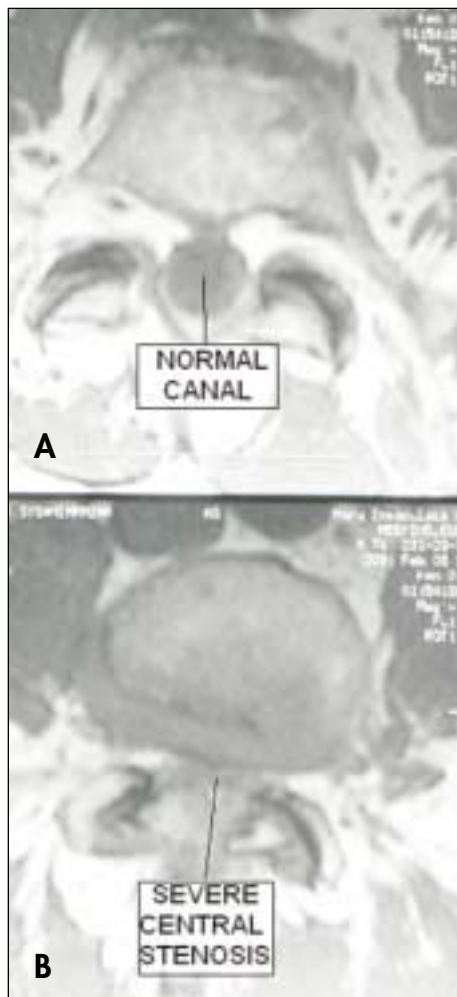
A & B. Central spinal stenosis shown with its characteristic overgrowth of the posterior ligament and overgrowth (arthritis) of the facet joint. These are mid-sagittal (side view of front-back) slice parallel MRI scans, 5mm apart, side by side. Decompression is principally directed towards removing the ligamentous hump.
